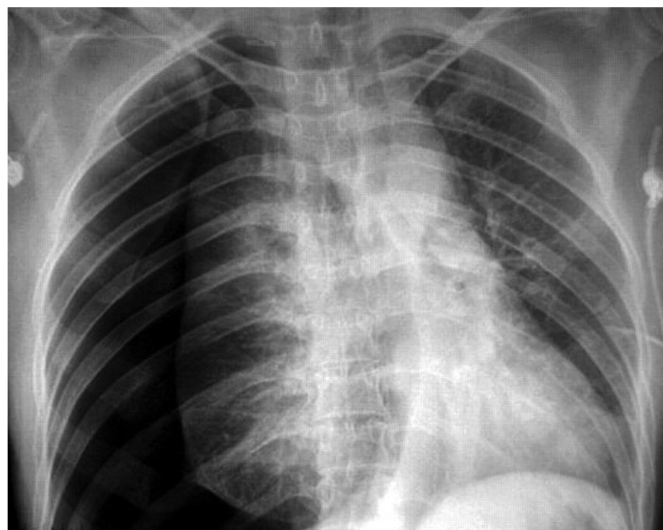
Chest X-ray, anterior projection. A right-sided large pneumothorax is determined by the appearance of a vertical line corresponding to the image of the visceral pleura pushed back due to pneumothorax.
